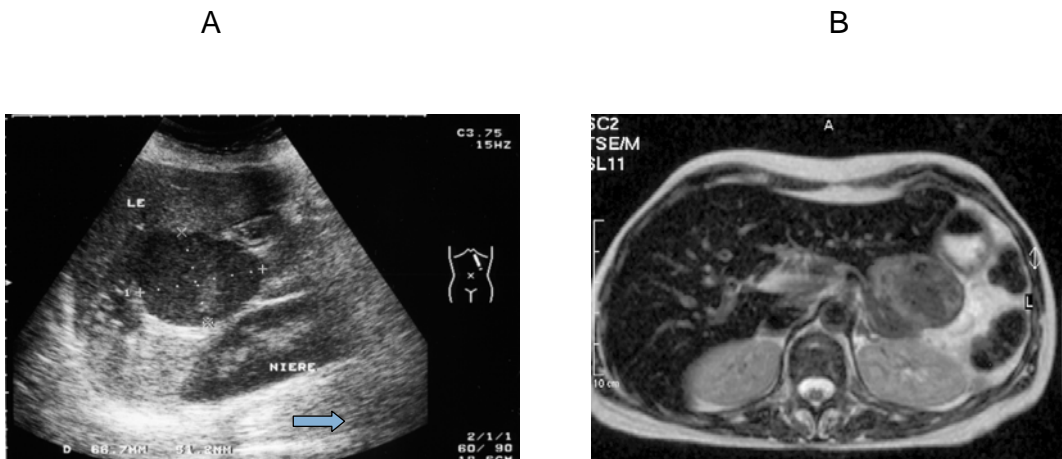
Gaucher cell pseudotumour adjacent to the liver. Typical ultrasound (A) and MR (B) aspect of a pseudotumour-like parahepatic, hyperechoic, hypointense lesion, suspicious of a solid lesion like HCC or metastasis. Biopsy revealed no hepatocytes, but only Gaucher cells, see also [22].
